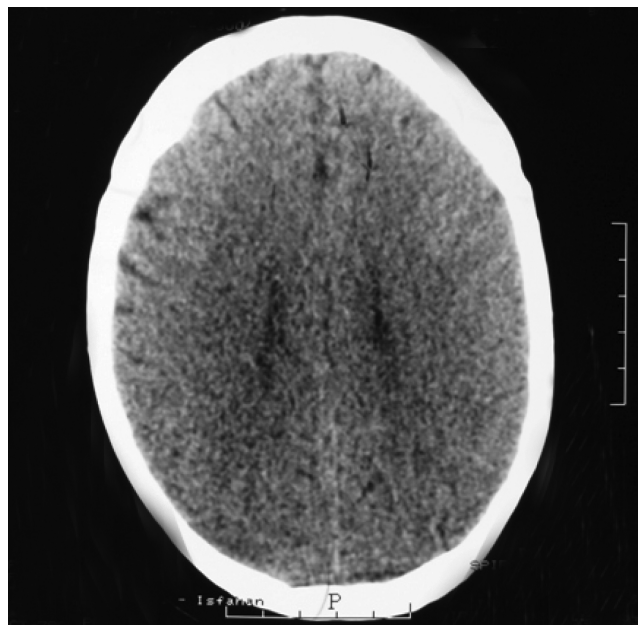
MRI imaging demonstrated no abnormality in brain and thickness of scalp measured as 17 mm
